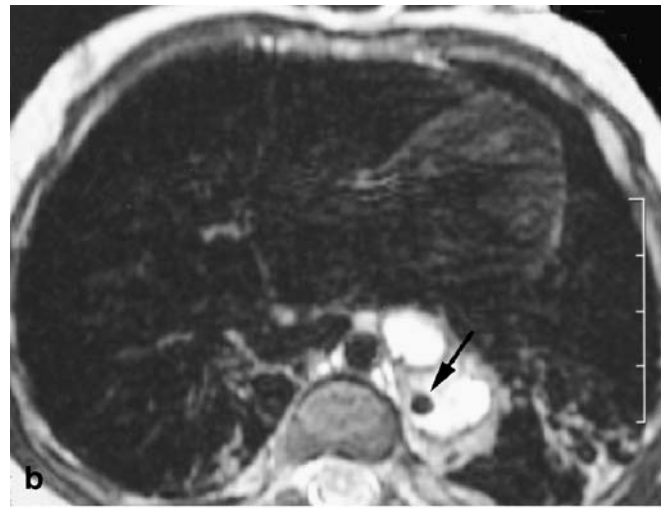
Foregut malformation (bronchogenic cyst and extralobar cystic sequestration) with gastrointestinal connection. This 5-month-old boy with prior repair of tracheoesophageal fistula had persistent respiratory and feeding problems. An MR image obtained to evaluate for vascular ring demonstrated instead a complex cystic and solid malformation in the left lower lobe. a The sagittal T1-weighted image demonstrates a superomedial large cyst (bronchogenic cyst) (*arrow*) and a more inferior more solid mass supplied by a systemic abdominal artery (*arrowhead*) and containing several
